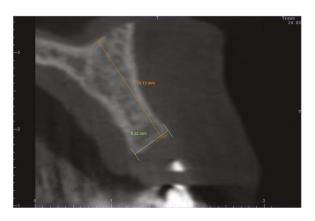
CBCT sagittal image showing bone reconstruction, after 6-month period, with graftless bone reconstruction technique.
